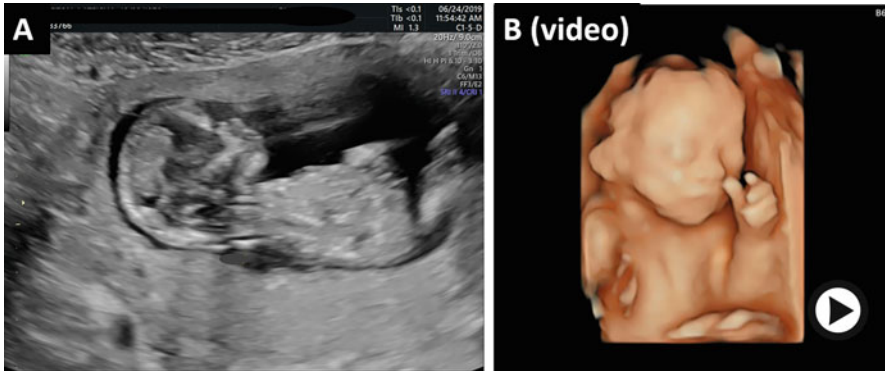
(Video 10.3) Panel A shows ultrasound image of a first trimester fetus. Panel B shows 4D video imaging in real-time of a 20 week fetus performed at the time of an anatomy survey. This video demonstrates the *in utero* fetal movements that make it challenging to obtain measurements of fetal structures and evaluate for fetal anomalies (▶ <https://doi.org/10.1007/000-7qr>)
